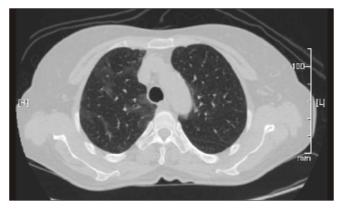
CT scan of lung with infiltrates
